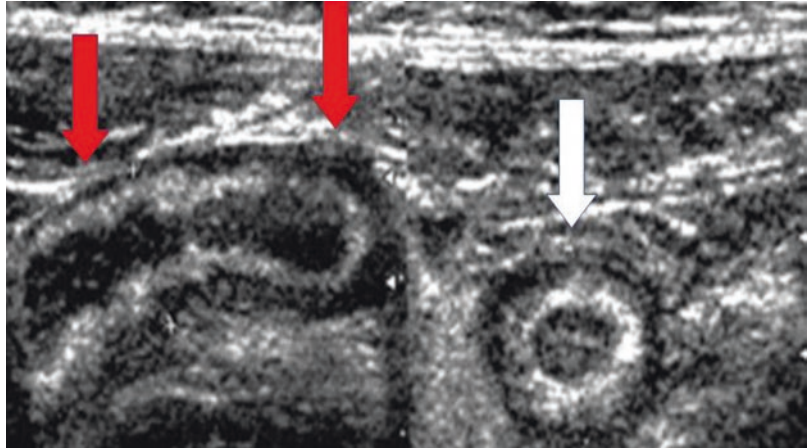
Ultrasound image of a patient with appendicitis. Notice the thickened edematous wall and fluid-filled lumen (possibly pus) in sagittal section (red arrows, image on left), and axial section (white arrow, image on right)
